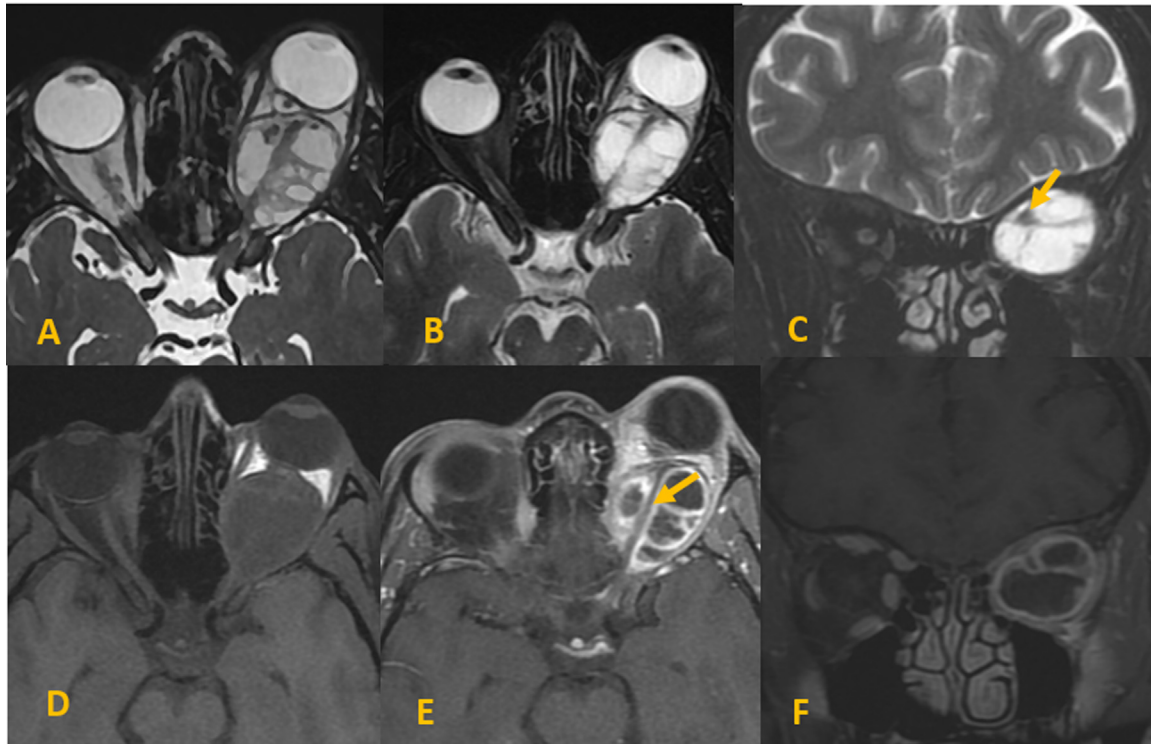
Intraconal process around the left optic nerve (yellow arrow) with low signal on T1-weighted ponderation (D), high signal on T2-weighted images (A, B, and C), and rim enhancement after intravenous gadolinium administration (E and F). The orbital mass caused grade II exophthalmia.
